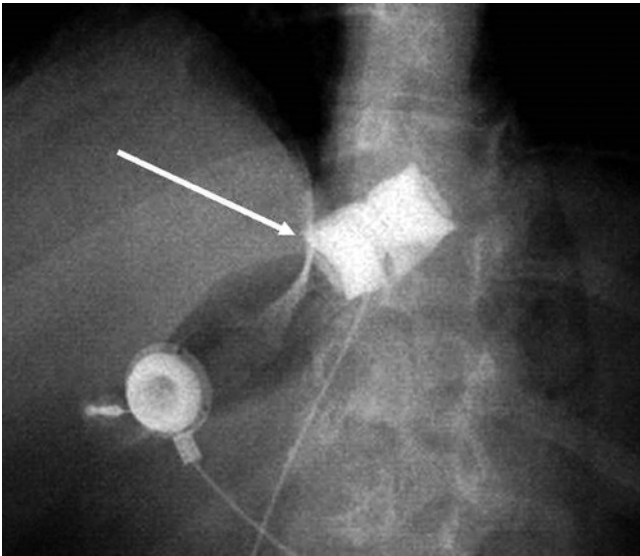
X-ray showing leakage of contrast (*arrow*) from gastric band
